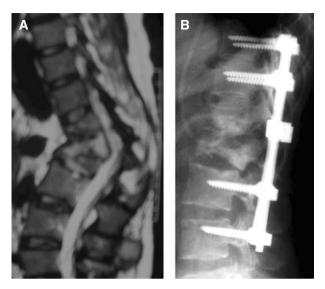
A T2-weighted sagittal MRI. Thoracolumbar Pott disease (Th12-L1-L2) with spinal cord compression due to vertebral body collapse with an important kyphosis (Cobb angle of 152°). B Postoperative thoracolumbar X-ray. Th12-L1-L2 lamino-arthrectomy with posterior laminectomy and posterior fixation (osteosynthesis with screws). Note kyphosis improvement (25°)
